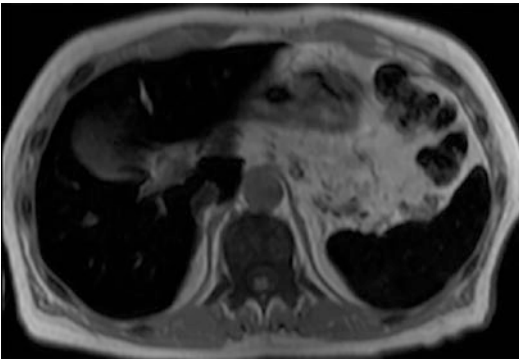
Axial T1-weighted in-phase imaging through the liver demonstrates low hepatosplenic signal
